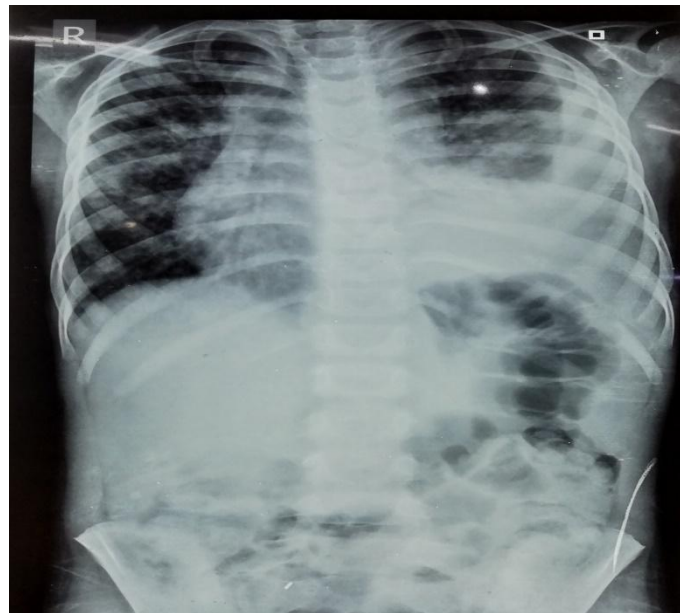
X-ray chest at the time of presentation
